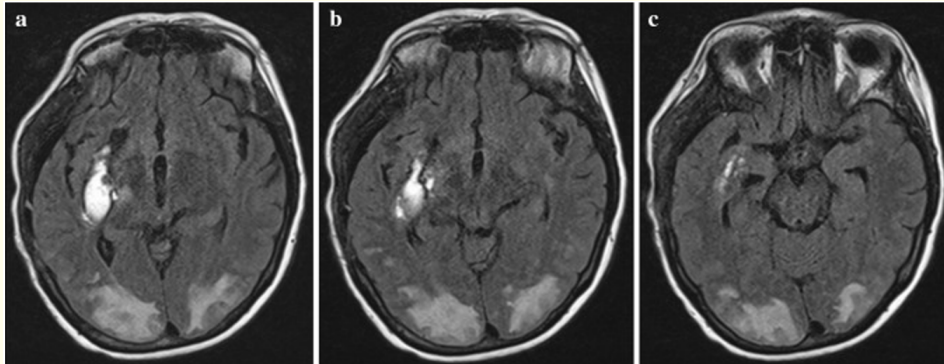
a-c Axial MR image (fluid-attenuated inversion recovery sequence) demonstrates extensive vasogenic edema in the occipital region bilaterally and right insular hemorrhage [9].
